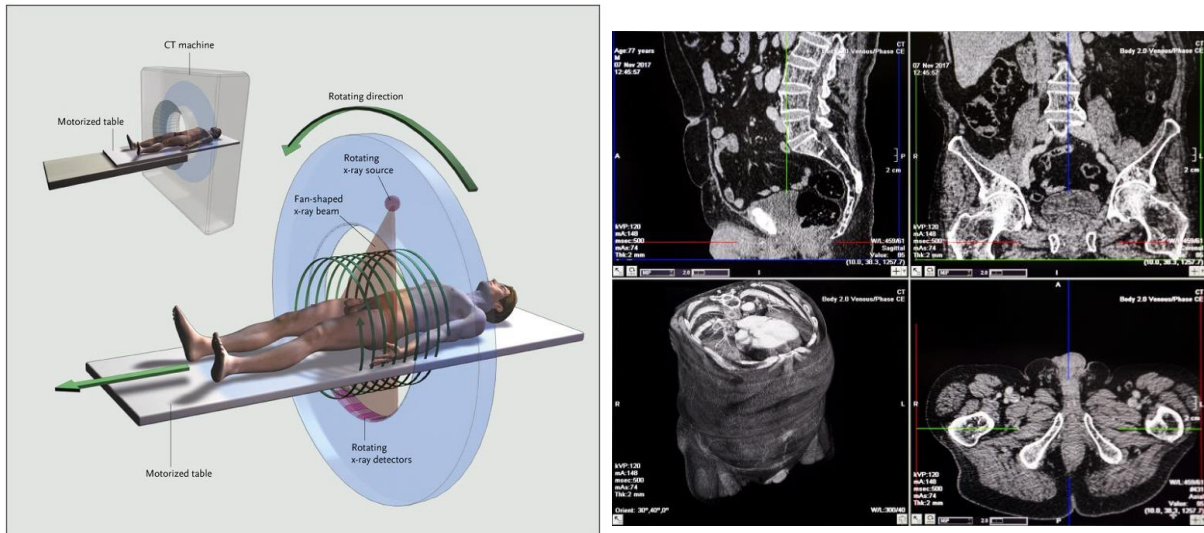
The principle of Computed Tomography: a rotating tube delivers a fan-beam of X-rays to the patient, and the transmitted fraction of this beam is measured in the opposing detector (left). After reconstruction, the densities of the tissues (bone, muscle, soft tissue, etc.) can be visualized as slices in the 3 directions (sagittal, coronal or transverse).
